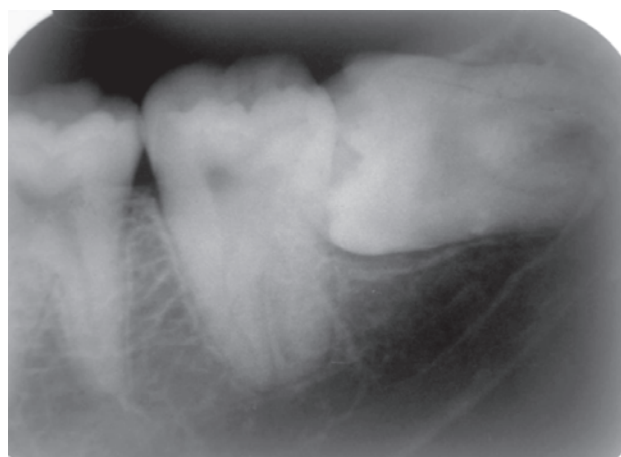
(A) Periapical X-ray showing 3 roots for 38, (B) OPG shows 3 roots for 48 also
